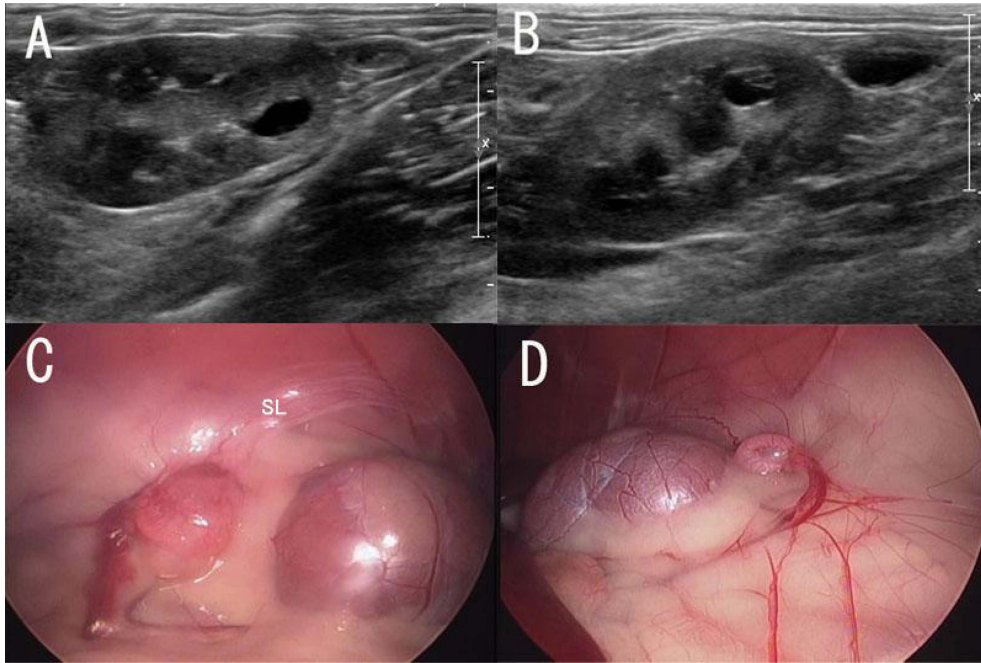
Ultrasonographic findings (A-right, B-left) and laparoscopic images (C-right, D-left) of ovarian remnant in a queen. Cyst-like hypoechoic structures are located directly caudal to the kidney of each side. Suspensory ligament (SL) and kidney are good landmarks.
